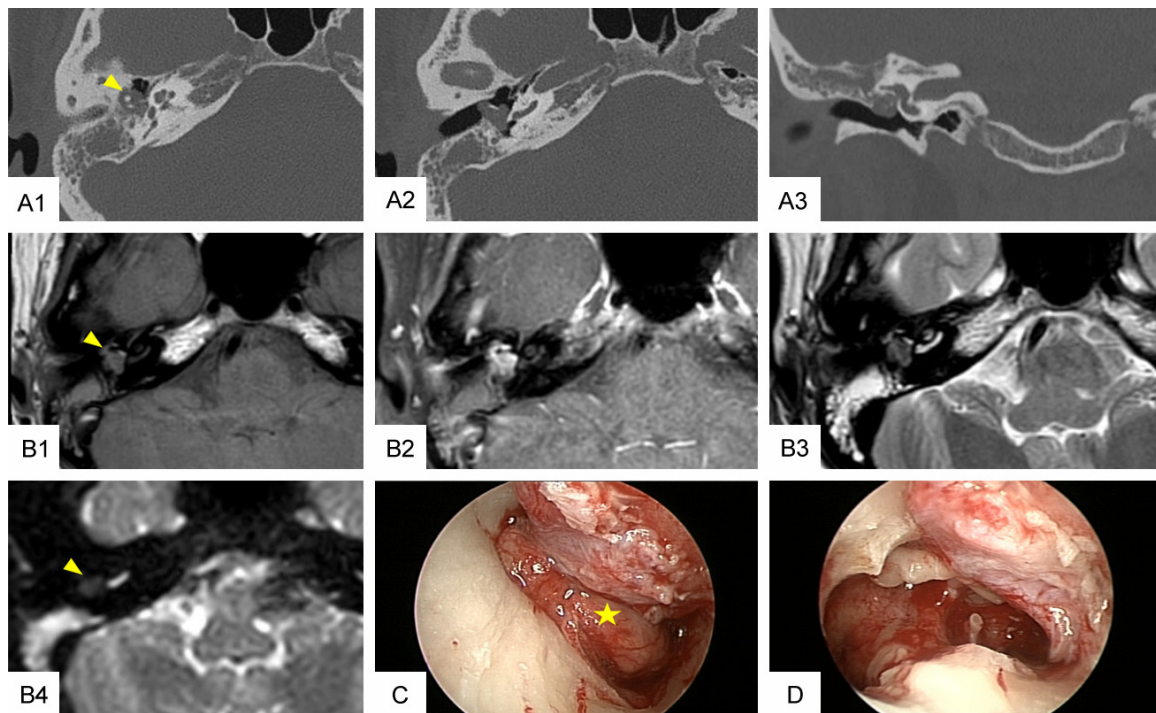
Intra-operative images of case 1. Soft-tissue density (yellow arrow) was observed in the tympanic cavity (TC), enveloping the ossicular chain on CT (A1, A2: axial; A3: coronal). MRI demonstrated isointense signals on both T1- and T2-weighted images (B1, B3), heterogeneous enhancement (B2), and no obvious diffusion restriction on DWI (B4). (C and D) show intra-operative endoscopic images, in which the tumor is indicated by a yellow asterisk.
